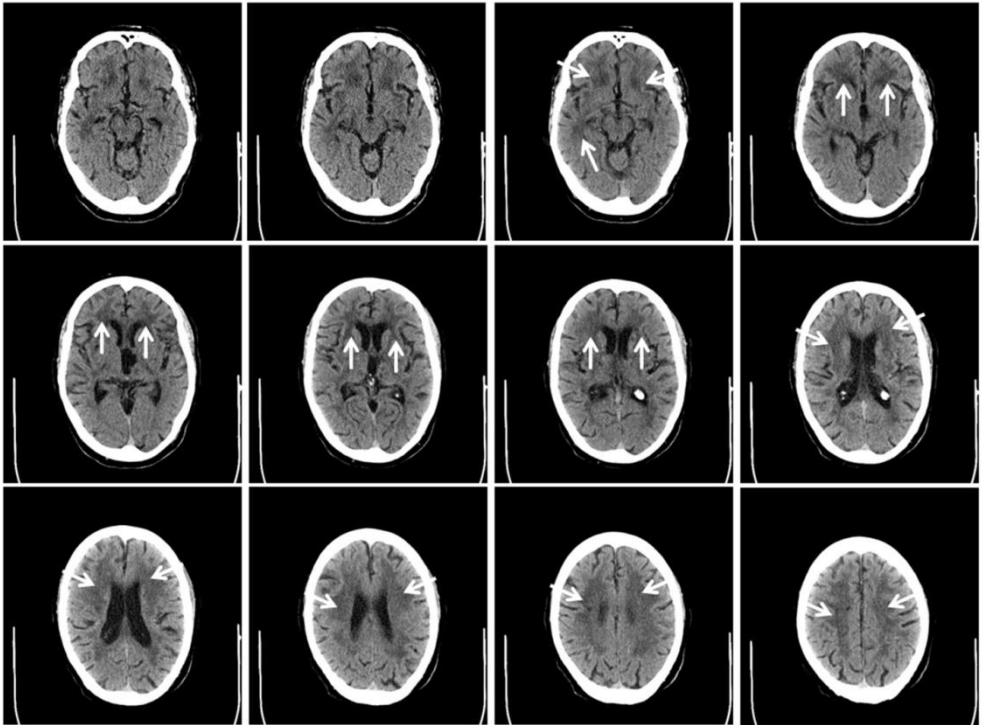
CT axial images from the brain of a patient diagnosed with CADASIL. White arrows indicate regions with white matter alterations. Images kindly provided by the Neurology Department of the Hospital La Princesa.
